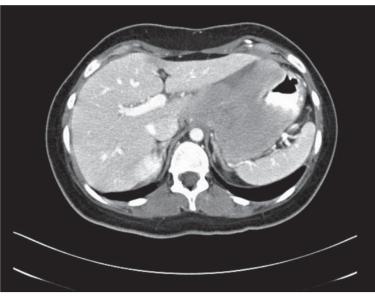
CT scan showing filling defect in the stomach wall.
